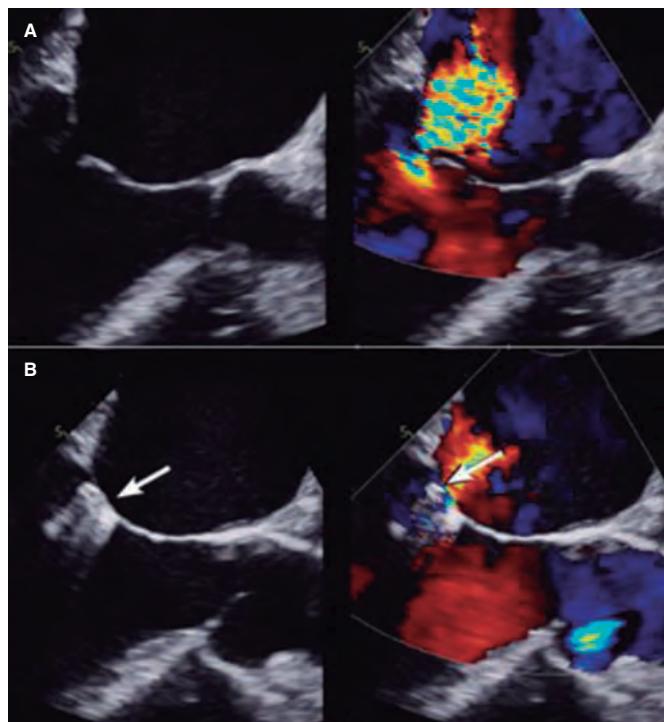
Two-dimensional transesophageal echocardiography image. A: mitral regurgitation before clip implantation. B: the clip appears like acoustic shadowing. The color image shows how difficult it is to assess the radius of the proximal isovelocity surface area (PISA) and the vena contracta due to clip interference (shown by the arrow). Reproduced with permission from Mayo Clinic.⁷
